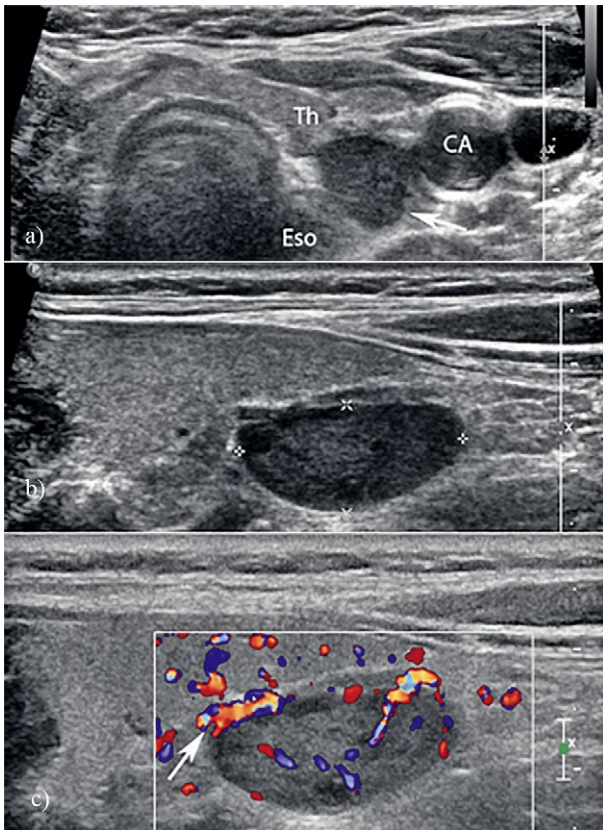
Parathyroid adenoma in a 44 year old female with elevated serum calcium levels. Transverse (a) and sagittal (b) US through the left lower neck showed a hypoechoic mass posterior to the thyroid gland (Th). CA – carotid artery, Eso – esophagus. Color Doppler US (c) showed significant internal vascularity and an enlarged inferior thyroid artery (arrow).
